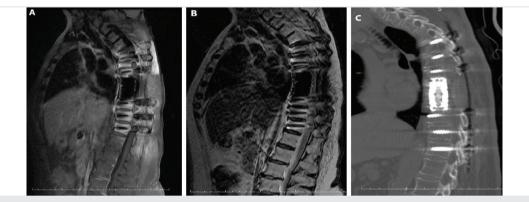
(a) Post-operative 1st-year T1W contrast-enhanced sagittal magnetic resonance imaging (MRI) showed no signs of infection in the disc, vertebral corpuscles, or epidural distance. (b) Unenhanced T1W sagittal MRI showing no evidence of infection. (c) Post-operative 1st-year sagittal multi-planar reconcomputed tomography showed no signs of infection
